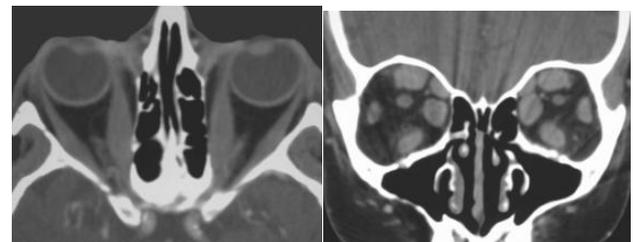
CT scan of orbit (coronal & axial slices) showing swollen extra-ocular muscles , sparing their tendons in thyroid ophthalmopathy.
